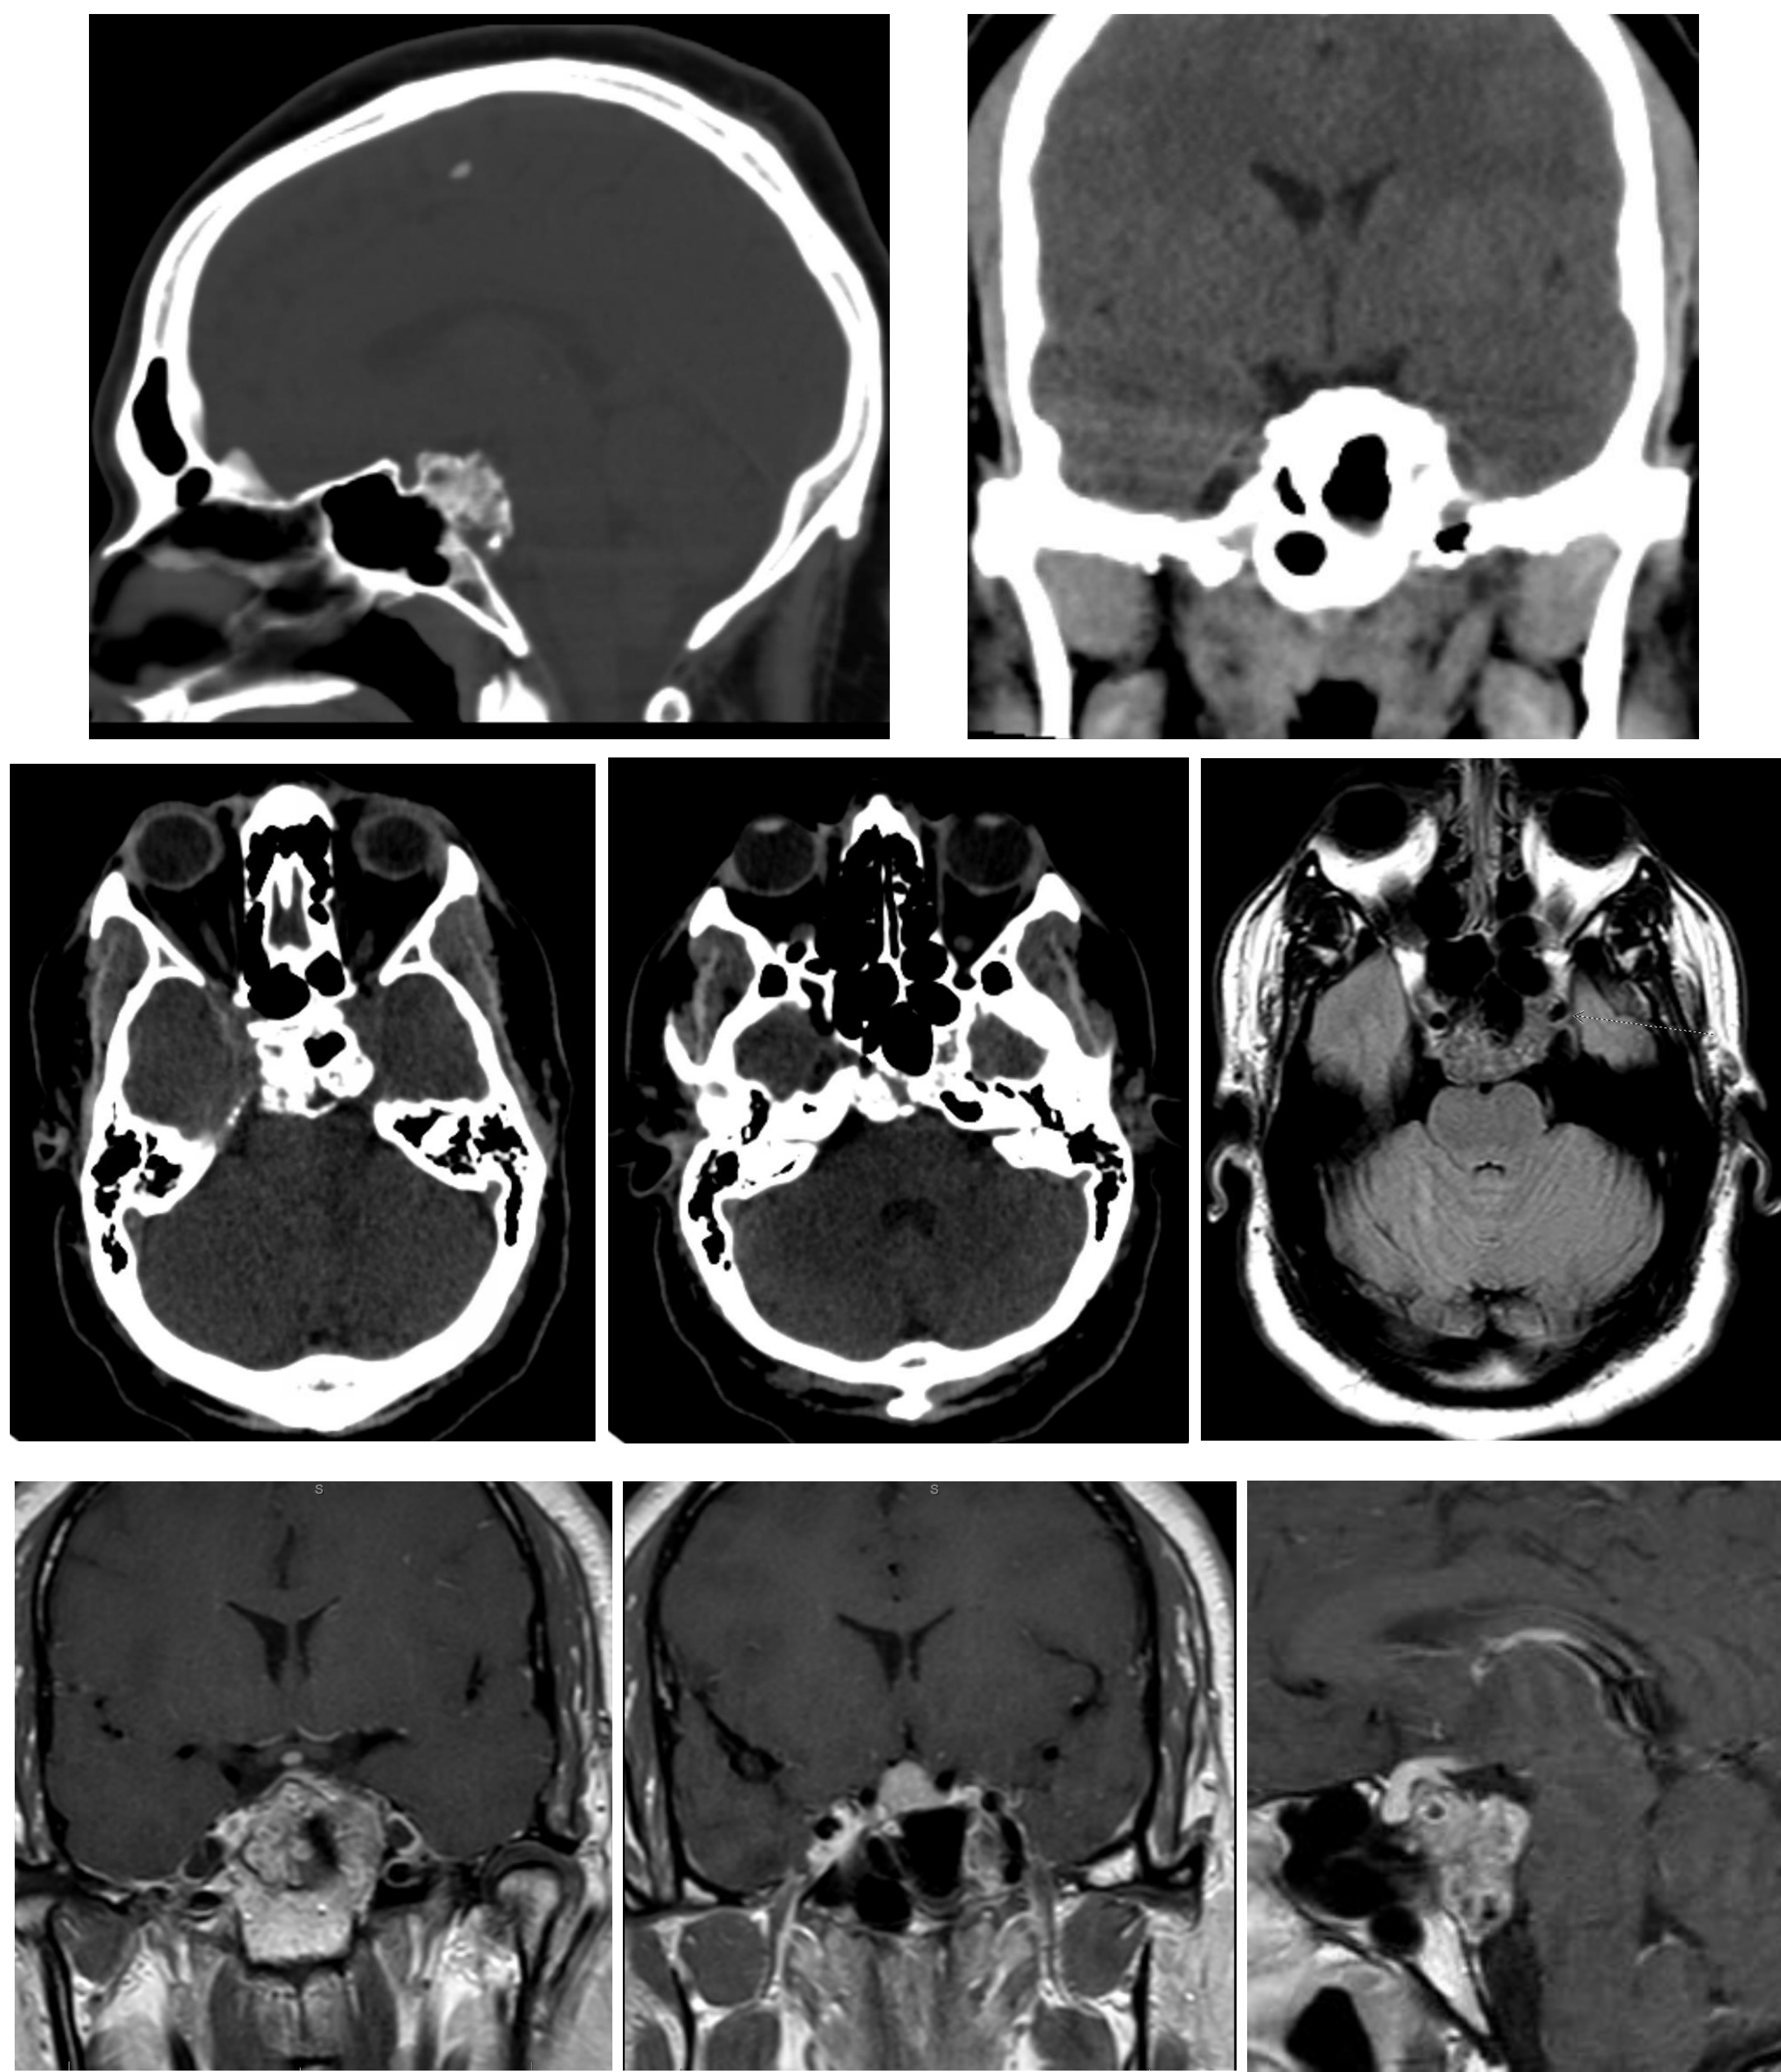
Preoperative CT scan and MRI.
